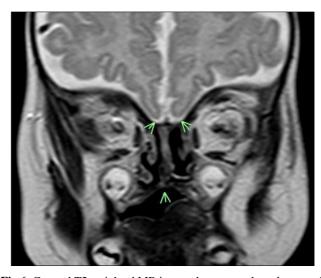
Coronal T2 weighted MR image shows complete absence of the olfactory bulbs and sulci bilaterally, with no identifiable olfactory structures along the cribriform plate. Note is made of high arched palate.
